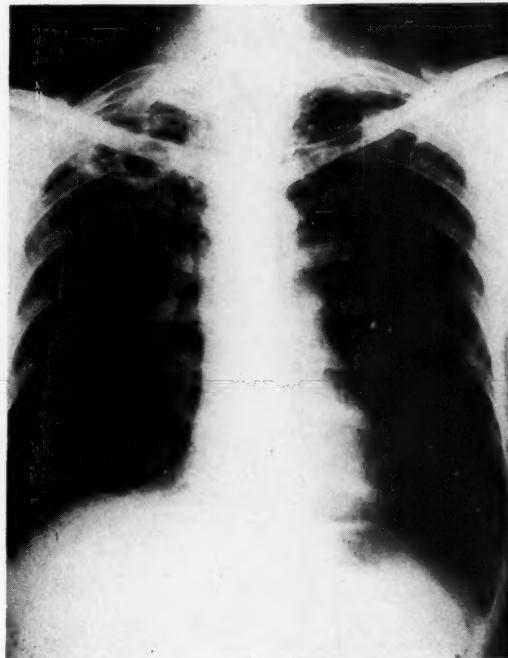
(a) X-rays of chest of patient with bilateral apical cavitation treated by apicolytic and "lucite" plombage.
